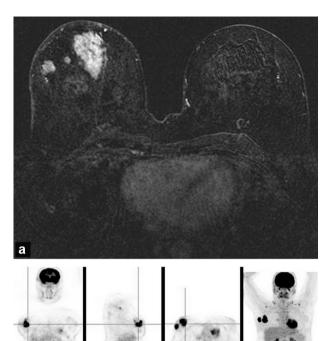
a: breast MRI at the time of the breast lymphoma; b: PET-scan at the time of the breast lymphoma: one breast spot.
